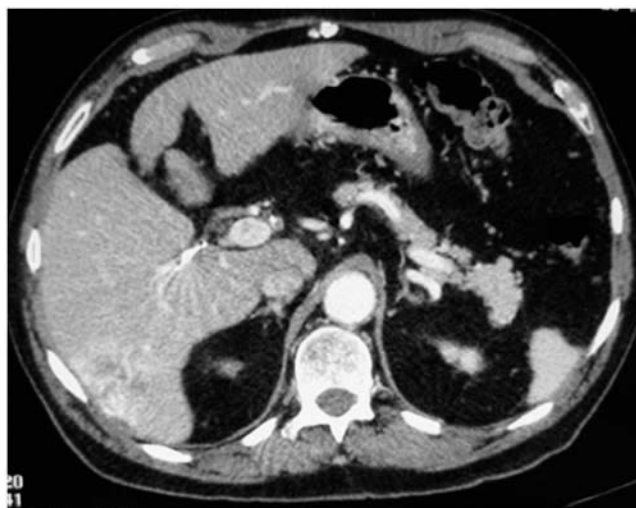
Check-up CT after 4 weeks post-chemoembolisation, where tumour necrosis is observed and area with arterial ischaemia (segments VI and VII).
